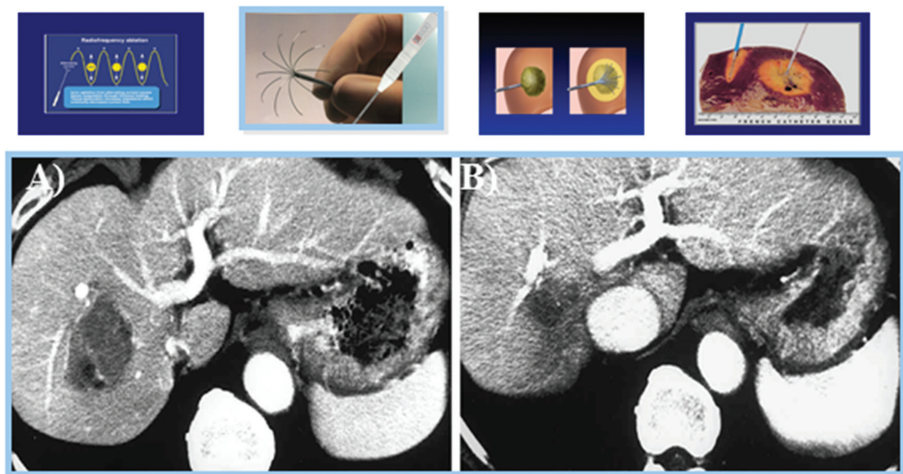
Image-guided radiofrequency ablation for hepatocellular carcinoma. Under ultrasound-guidance, a radiofrequency ablation needle is placed near the center of the tumor. A. Alternate current at high frequency turns the needle tip temperature into a thermal injury with a subsequent death zone. B. At 3 months follow-up, the death zone has contracted.
